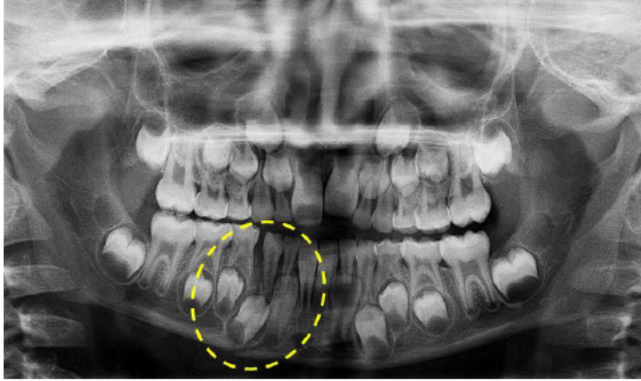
Preoperative Orthopantomograph
